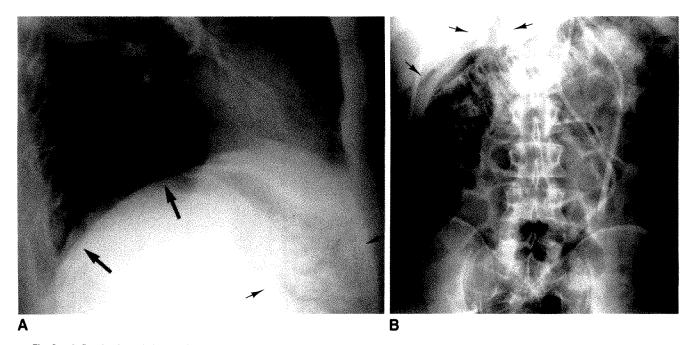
A, Routine lateral chest radiograph made 39 days after transplantation shows gas in bowel in abdomen (small arrows). Pneumoperitoneum also is present (large arrows).
